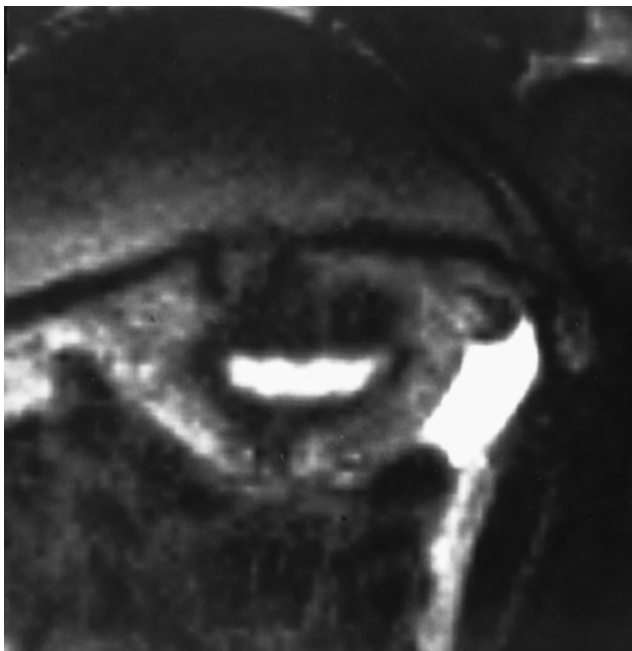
Magnetic resonance imaging of the uterus of a woman with endometriosis in a coronal section. The image shows a preponderance of the archimetrial infiltrations near the sagittal midline.
